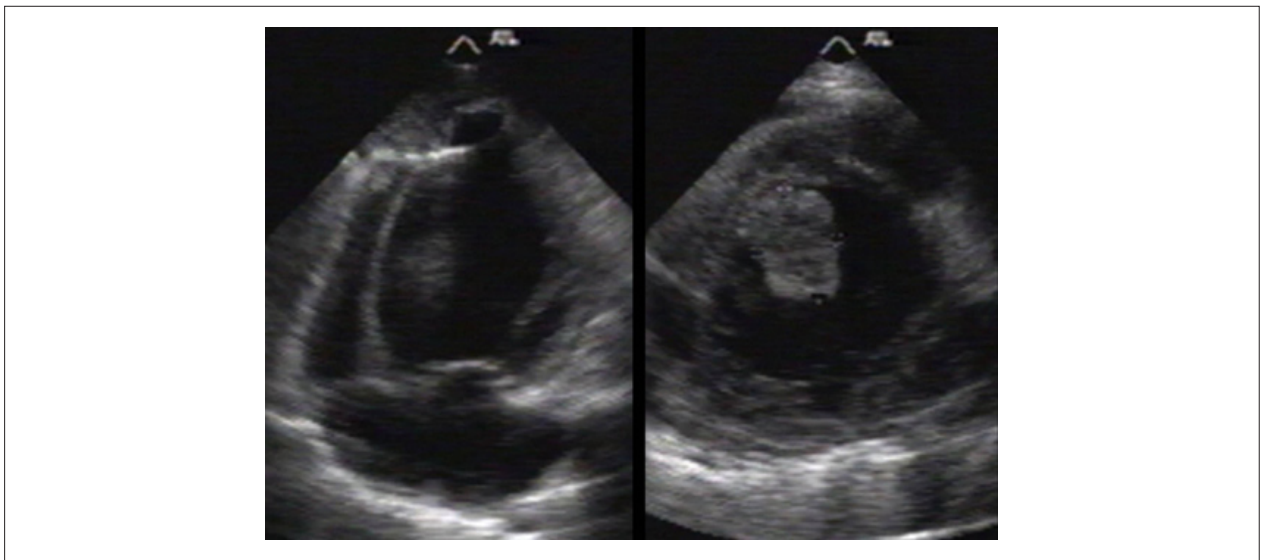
and 1B - Transthoracic echocardiogram. Pseudoaneurysm in the LV apical region with thrombus inside it and thrombus in the ventricular cavity.
